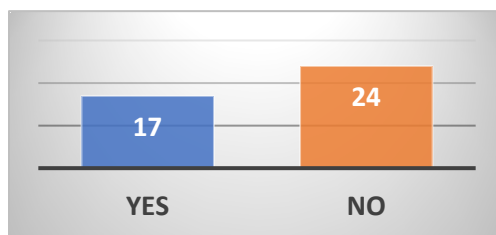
Do you find that DWI defendants fall under the CCP 16.22?
